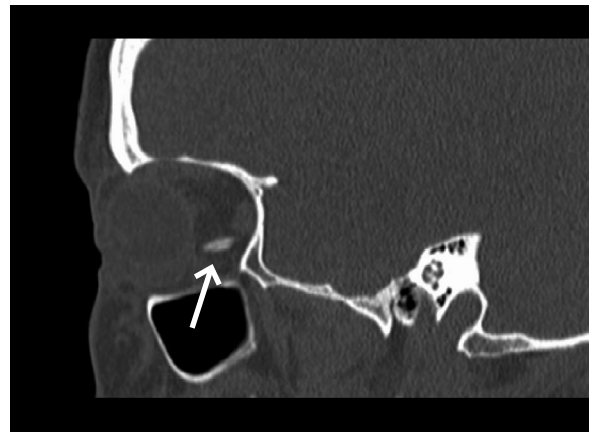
A repeated CT scan showed a residual foreign body (white arrow) seen in the retrobulbar space next to the posterior third of the lateral rectus muscle.
